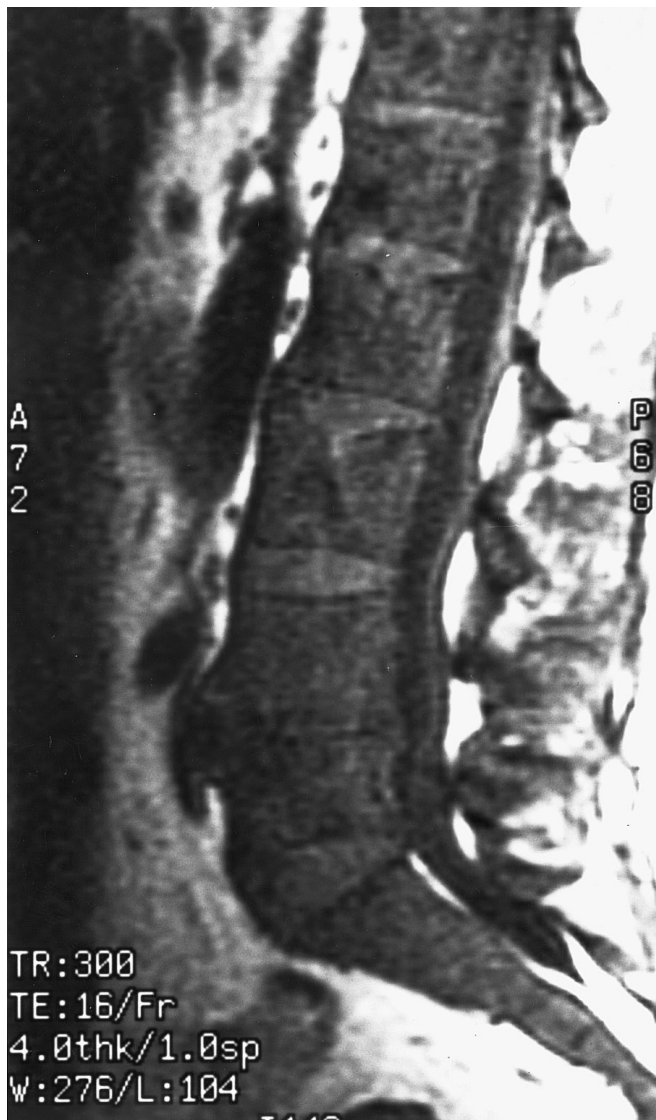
Magnetic resonance image of the spine demonstrating diffuse replacement of the normal fatty marrow constituent by some other foreign tissue.
